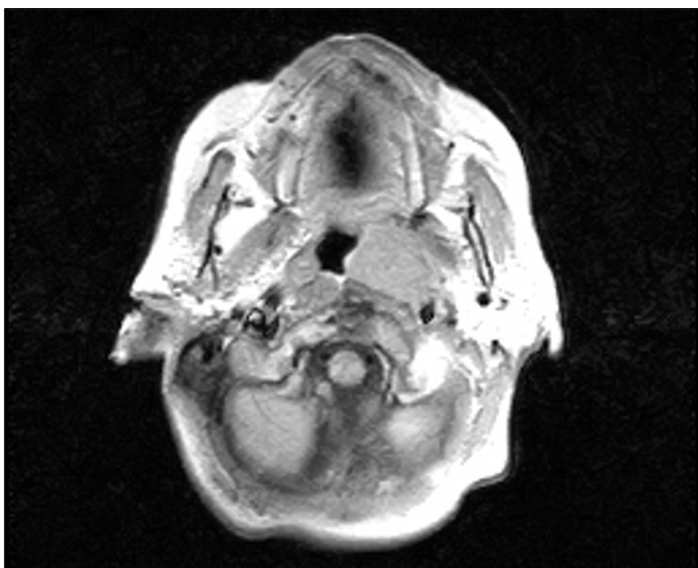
Axial view of the nasopharynx and the mass on T1-weighted MRI (before treatment)
